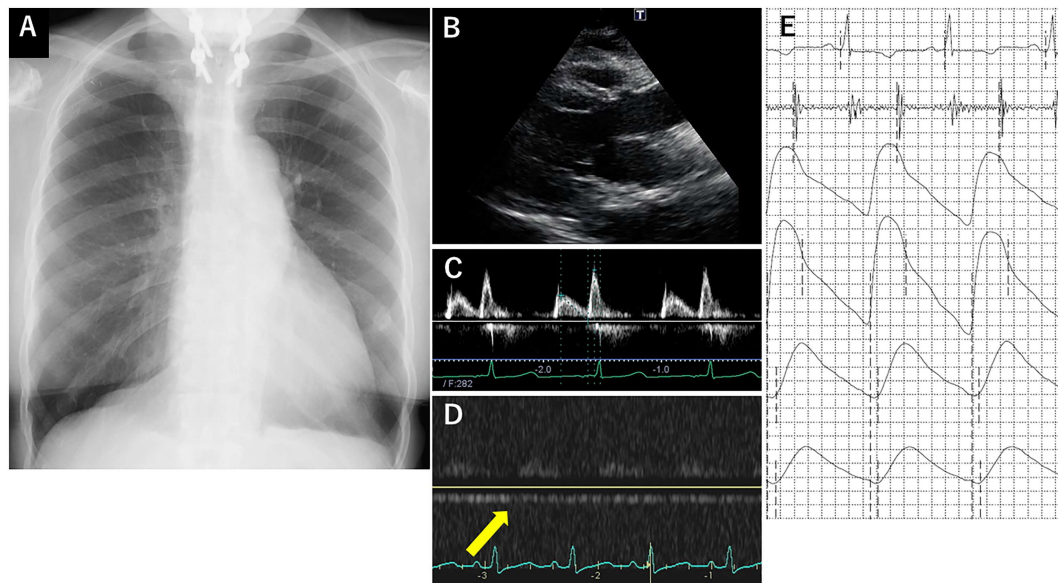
Postoperative examination. (A) The CTR decreased to 53%. (B, C) An echocardiography showed increased EF (55%), decreased LAVI (26 mL/m²), and improved left atrial pressure (E/A 0.5, DT 229 ms, i.e. abnormal relaxation pattern). (D) The intrarenal venous flow pattern improved to continuous pattern (yellow arrow) which suggests no renal congestion. (E) ABI increased to 0.6.
